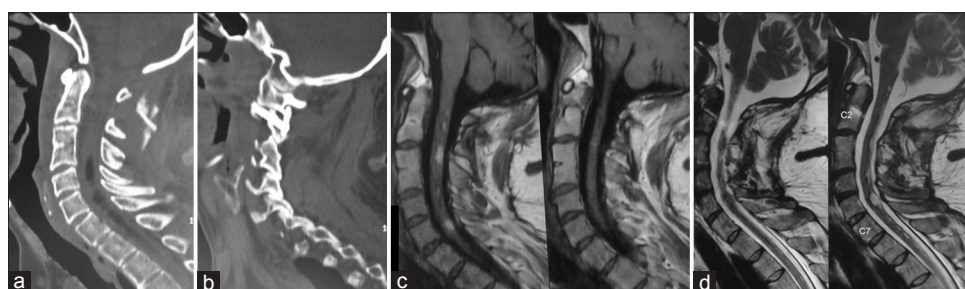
Postoperative images. (a) Postoperative computed tomography image. (b) Postoperative computed tomography image showing the fixation. (c) Delayed postoperative (after 27 months) T1 weighted image showing regression in the fat globules in the central canal. (d) Delayed postoperative (after 27 months) T2 weighted image showing significant regression in the hyperintense signal in the central canal
